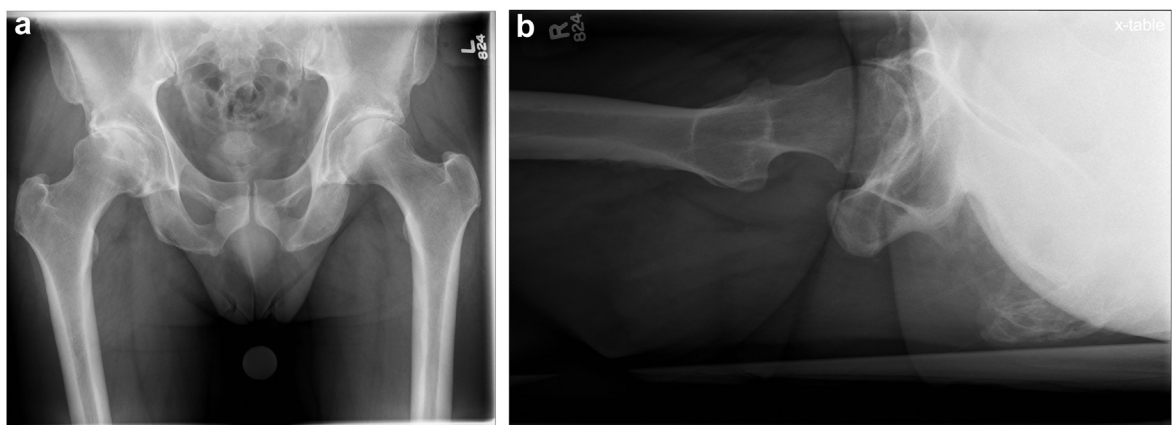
Anteroposterior (AP) low pelvis (a) and direct lateral (b) radiographs of a patient undergoing anterior muscle sparing total hip replacement. Note the large anterior acetabular osteophyte on a lateral radiograph. Assuming that this was normal, bony anatomy would lead to a poor acetabular component positioning (inappropriate anteversion). Not removing osteophyte could contribute to iliopsoas impingement and possible postoperative groin pain.
